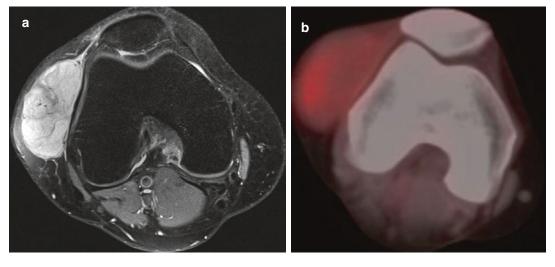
(a, b) *UPS* of the knee. (a) Axial STIR MR image. (b) Axial ¹⁸F-FDG PET-CT. The hyperintense subcutaneous soft tissue mass seen adjacent to the lateral
